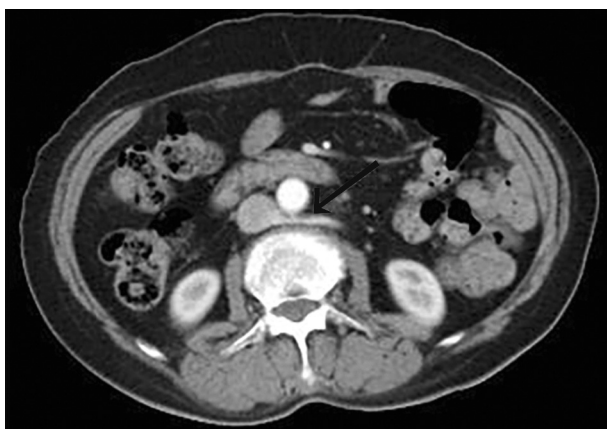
CT images revealed RLRV (red arrow) passing posteriorly to the abdominal aorta
